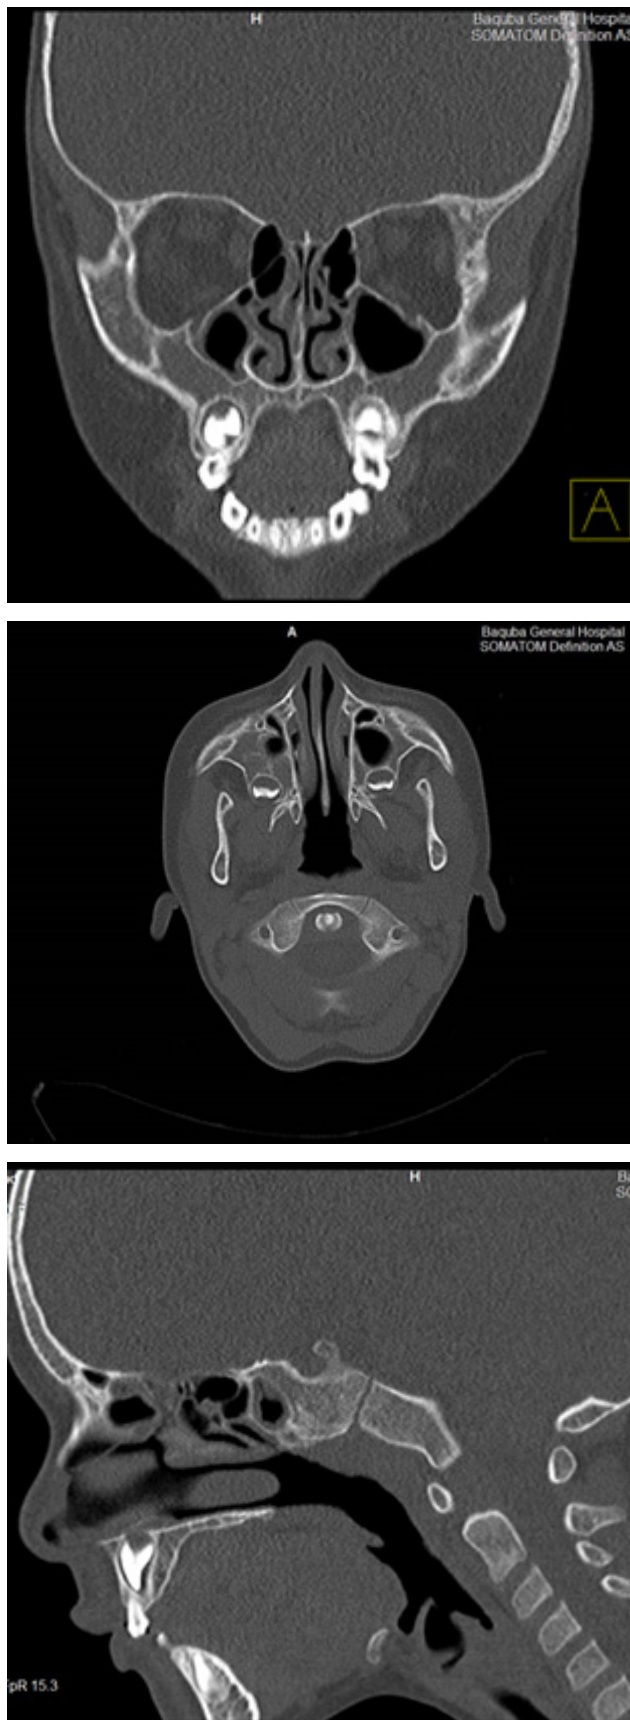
coronal, axial and sagittal section CT scan of nose and paranasal sinuses in 6 years old boy with thalassemia showing mucosal thickening in sphenoid sinus and Rt. maxillary sinus.
